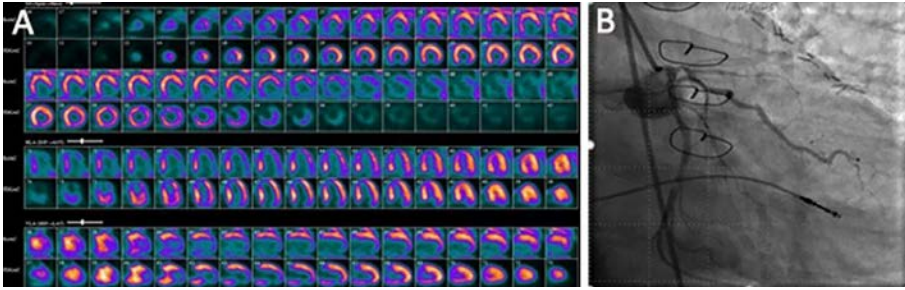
Rest ^{13}N ammonia PET-CT, ^{18}F -FDG-PET-CT and invasive coronary angiography. The ^{13}N ammonia images (A) depict a large and severe perfusion defect in the entire inferior and inferolateral walls and apex. The ^{18}F -FDG images depict significant mismatch (hypoperfusion with preserved glucose utilization) in most of the inferior and inferolateral segments, consistent with hibernating myocardium. Invasive coronary angiogram (B) confirmed a tight stenosis in the left circumflex coronary artery, which was revascularized.
